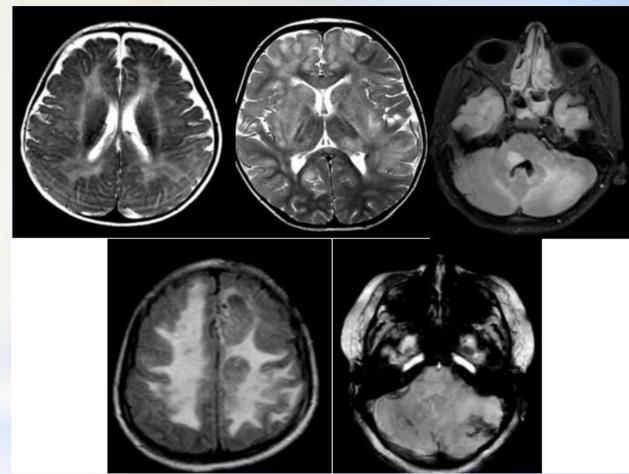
Patterns of MRI in patients with CNS-HLH. A) Axial T2 showing leukodystrophy like pattern. B) Axial T2 showing ADEM like pattern. C&D) Axial FLAIR and F) Axial SWI images showing complex pattern
